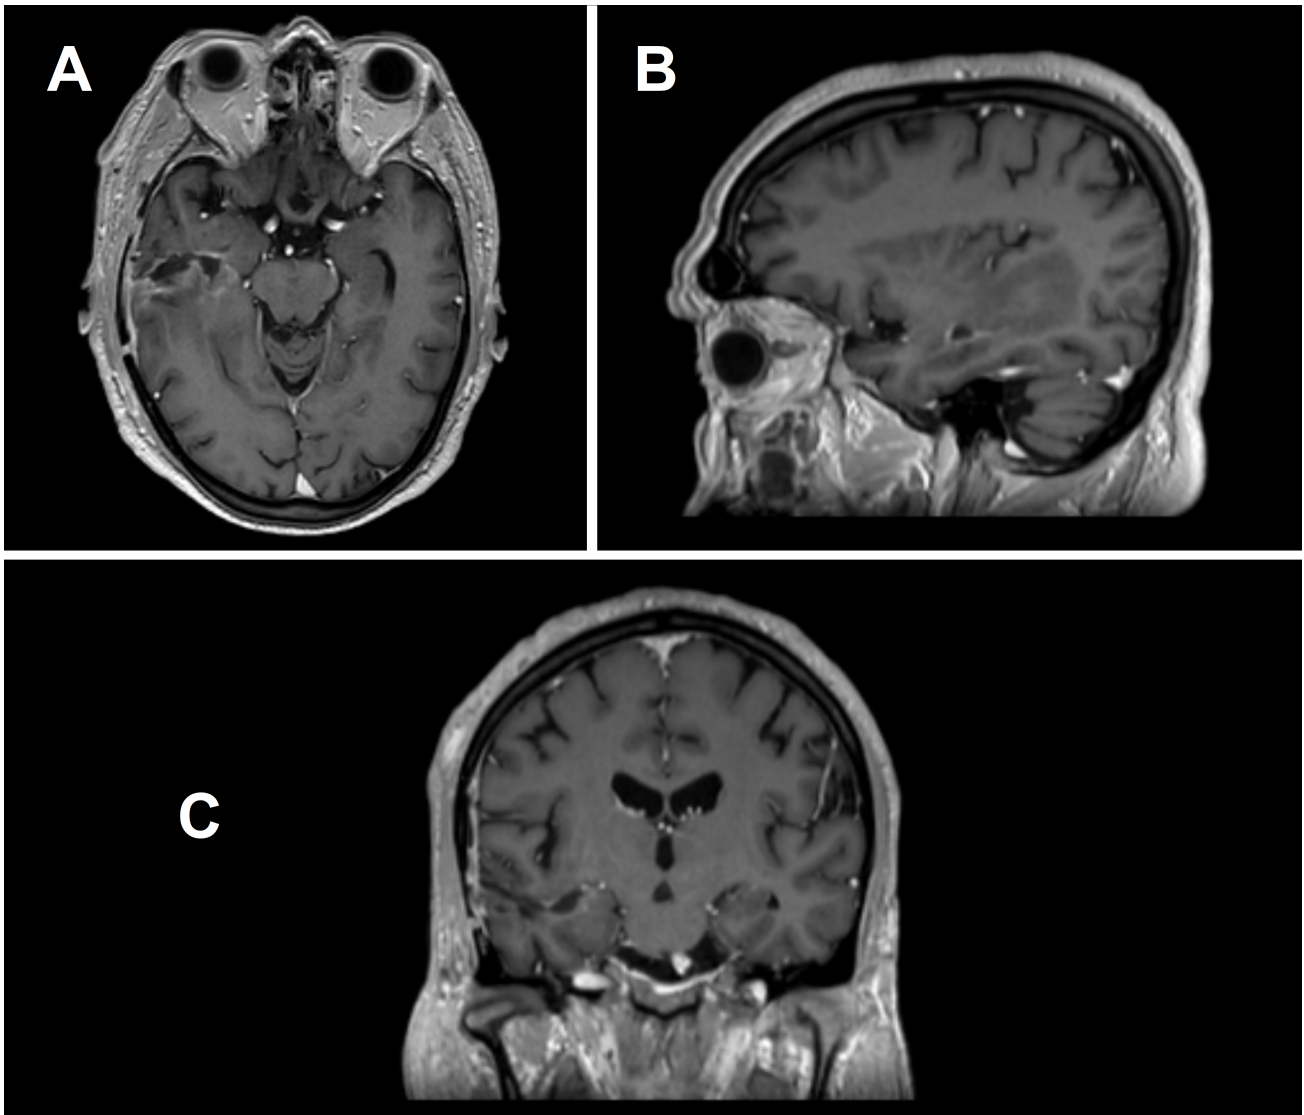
Postoperative MRI scans of the brain with gadolinium contrast were performed to assess for complications and evaluate the extent of resection. These images (A) axial, (B) sagittal, and (C) coronal sequences demonstrate satisfactory surgical outcomes, showing gross total resection of the temporal mass. There is resolution of the midline shift and ventricular dilation, indicating successful intervention and no significant postoperative complications. This image is from Garibaldi Hospital, Catania, Italy, and informed consent was obtained from the patient for this study.
